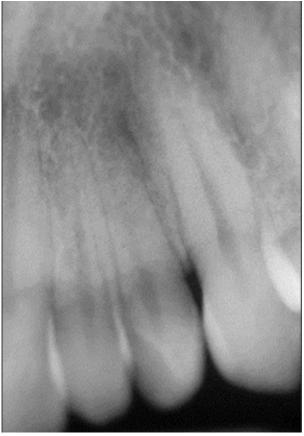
Periapical radiograph of maxillary lateral incisor tooth #10 with complete division.
